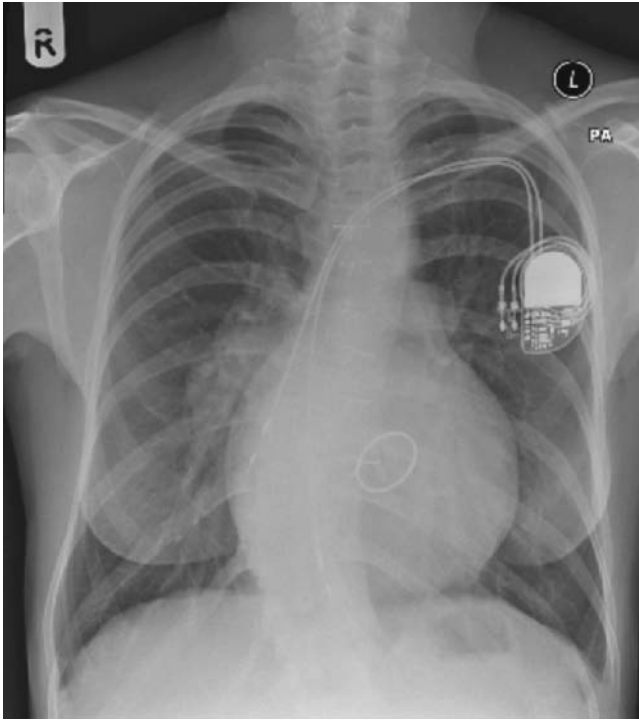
Postoperative chest x-ray of a patient with cTGA, mesocardia, and a scoliosis. There is a dual-chamber permanent pacemaker. The ventricular lead is in the subpulmonary morphological LV. There is a 33-mm St. Jude TV.
